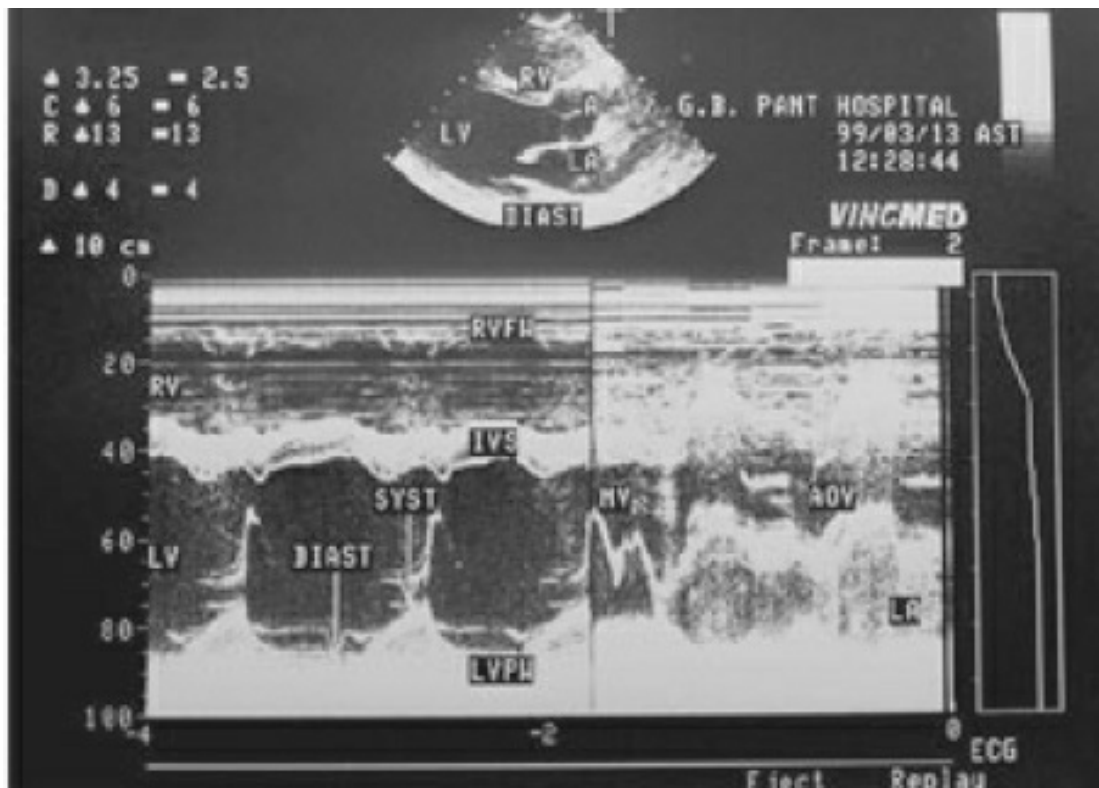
A typical M-mode echocardiogram (LA: left atrium, LV: left ventricle, RV: right ventricle, A: aorta, RVFW: right ventricular free wall, IVS: interventricular septum, LVPW: left ventricular posterior wall, MV: mitral valve, AOV: aortic valve).
